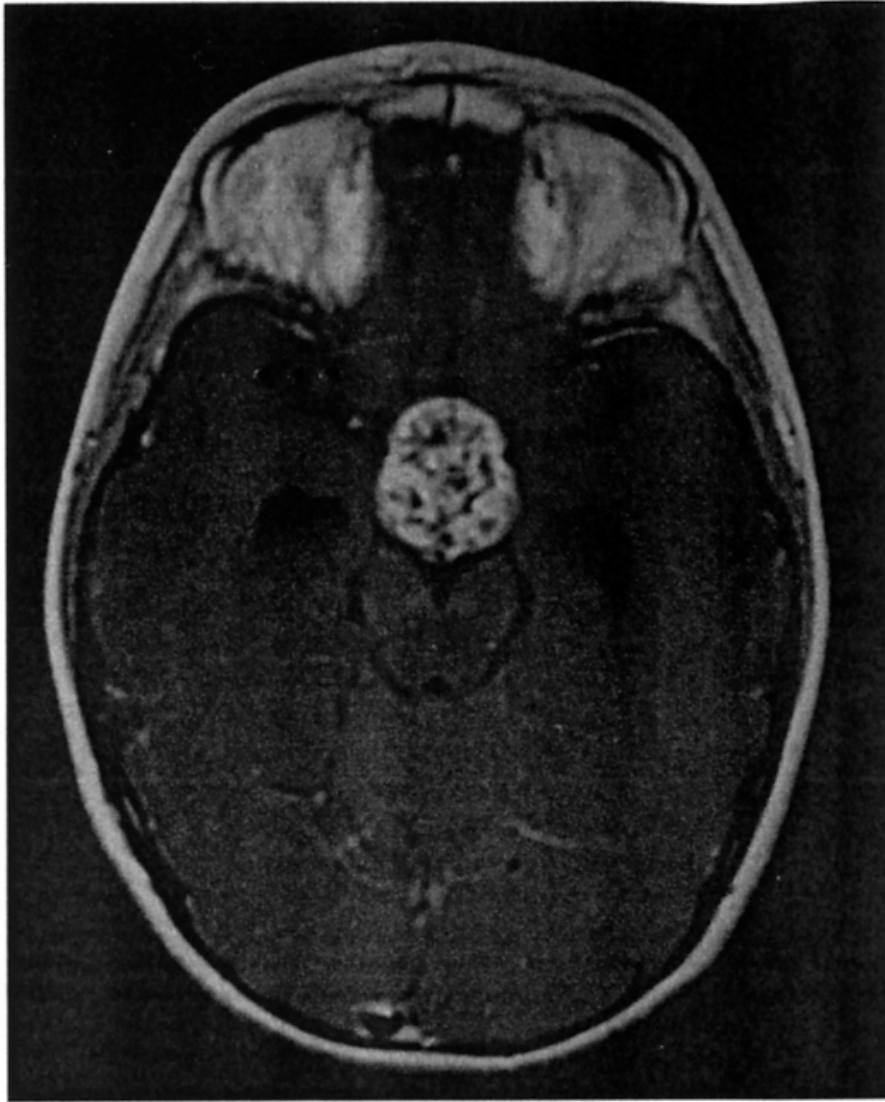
Axial T2-weighted MR imaging scan of an 8-year-old child with an intrinsic diffusely infiltrative brainstem glioma involving the pons and compressing the IV ventricle. Note investment of the basilar artery (dark signal in the ventral portion of the tumor) by the exophytic component of the tumor.
